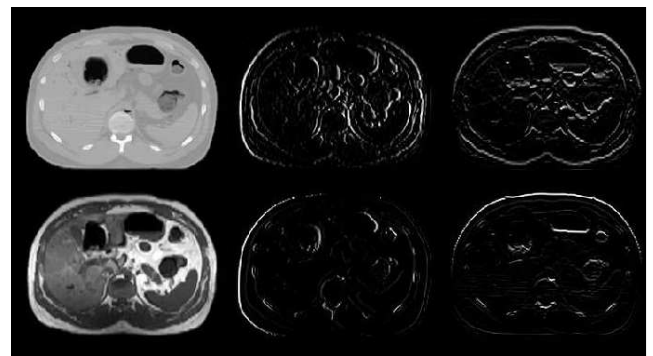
Discrete gradient transform using the 8th order approximation of an abdomen CT image on top row and MRI image on bottom row. From left to right: original image; transform in the horizontal direction; transform in the vertical direction.
